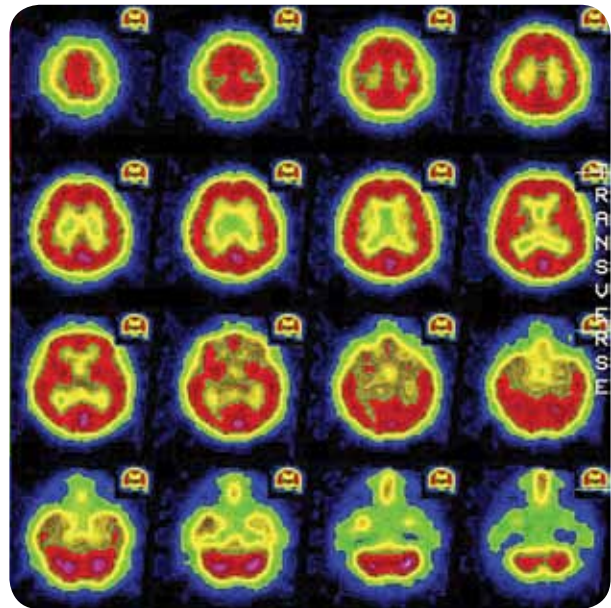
SPECT scans of a healthy human brain (top) and the brain of a person with Alzheimer's disease (bottom), showing less activity (areas in red). One advantage of SPECT is that a long-lasting radioactive tracer is used so research participants can be given longer tasks.
